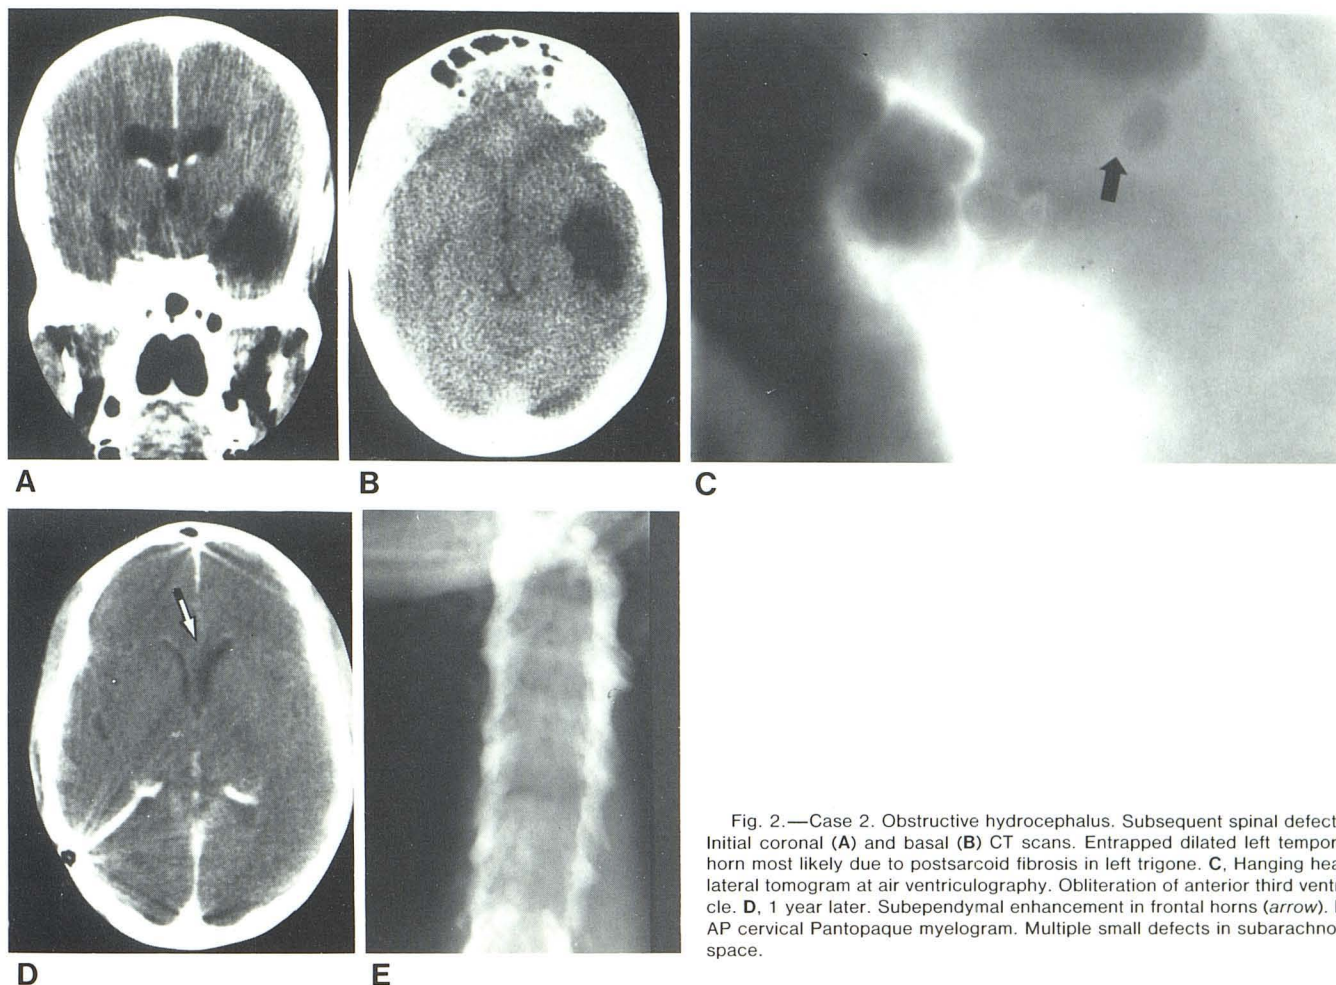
Case 2. Obstructive hydrocephalus. Subsequent spinal defects. Initial coronal (A) and basal (B) CT scans. Entrapped dilated left temporal horn most likely due to postsarcoid fibrosis in left trigone. C, Hanging head lateral tomogram at air ventriculography. Obliteration of anterior third ventricle. D, 1 year later. Subependymal enhancement in frontal horns (arrow). E, AP cervical Pantopaque myelogram. Multiple small defects in subarachnoid space.
